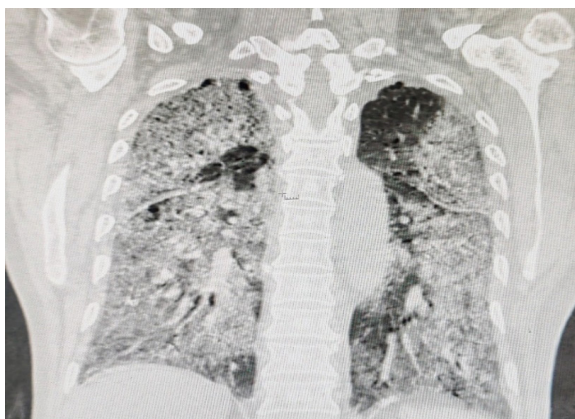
HRCT Coronal section showing diffuse ground glass opacities with interlobular septal thickening involving more than 75% of bilateral lungs. (Severity score: Severe involving > 75% of all the lobes)
